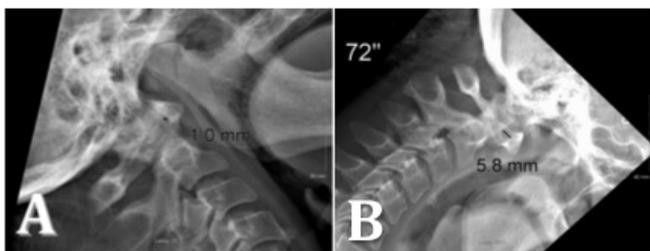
(A and B) Flexion-extension film of her cervical spine demonstrates atlantoaxial hypermobility. The atlanto-dental index increased from 1.0 mm to 5.8 mm on flexion/extension x-ray.
